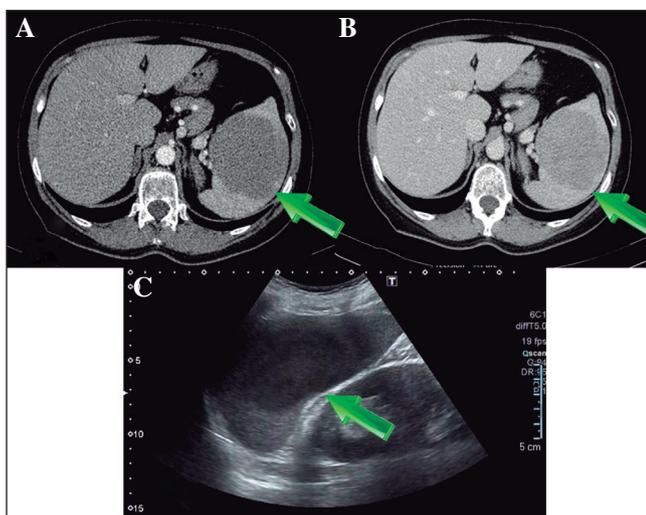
Abdominal CT. A. Arterial phase: hypodense behavior. B. Portal phase: little enhancement. C. Ultrasound scan: hypoechogenic lesion without a visible intralesional vascularization. The arrows are pointing to the lesion.
